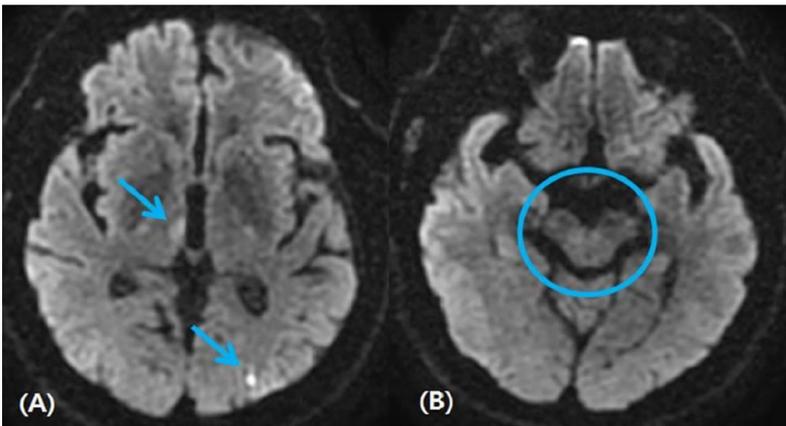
(A) Brain diffusion MRI revealing right thalamic and left occipital lobe infarcts. (B) Brain diffusion MRI did not reveal evidence of ischemia of the midbrain.
